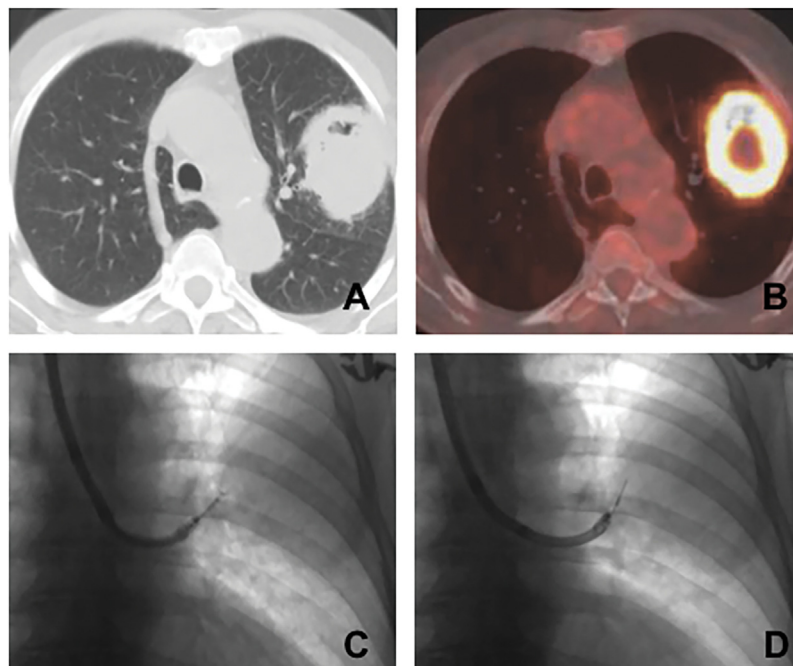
Chest computed tomography (A) and PET/CT scan (B) of a cavitated lesion in a patient with tuberculosis; conventional fluoroscopy-guided transbronchial biopsy (C) and needle aspiration (D) of the lesion.
